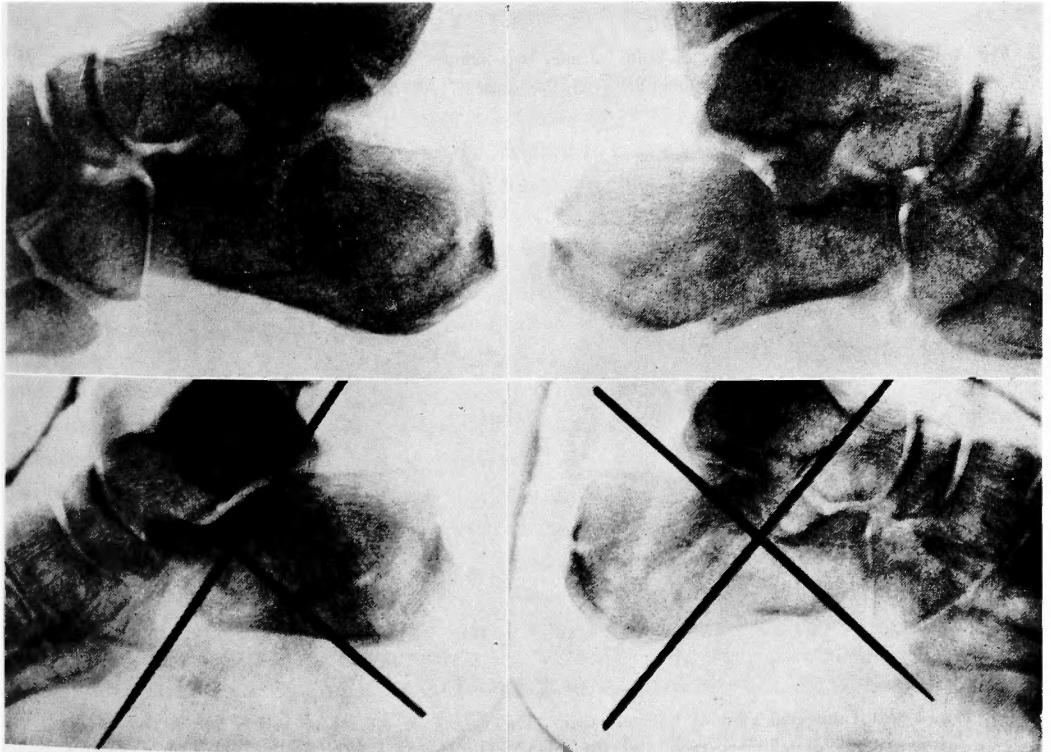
Case 1. Roentgenograms of both calcanei before and after surgery.
